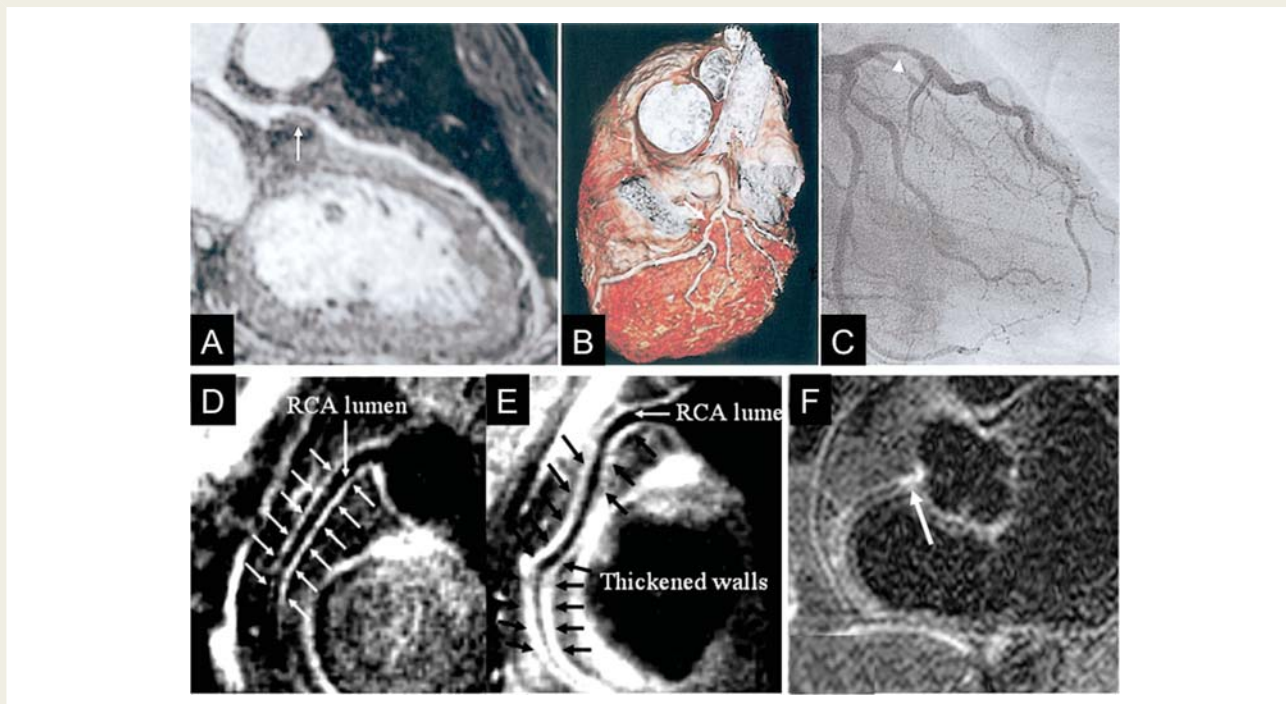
Visualization of a coronary atherosclerosis by MRI. (A) Curved multiplanar reconstruction of a whole-heart coronary MRA data acquisition shows a stenosis in the left anterior descending (LAD) artery (arrow). (B) Volume-rendering method in the same patient demonstrates three-dimensional view of the LAD with stenosis (white arrows). (C) X-ray coronary angiography confirms the stenosis of the proximal LAD (arrowhead),³⁸ reprinted with permission from Elsevier. (D and E) Coronary vessel wall images of the proximal RCA in two other subjects without coronary luminal stenoses; (D) a 58-year-old man with long-standing type 1 diabetes and normoalbuminuria and (E) a 44-year-old man with long-standing type 1 diabetes and diabetic nephropathy. In (D), there is no evidence of atherosclerotic plaque. However, an increased atherosclerotic plaque burden is seen in (E). The anterior and posterior RCA walls are indicated by arrows⁴⁴ reprinted with permission from Wolters Kluwer Health. (F) Delayed focal gadolinium late enhancement of the proximal RCA (arrow) is shown in another patient with X-ray defined coronary artery disease in the same location,⁴⁸ reprinted by permission of the European Society of Cardiology.
